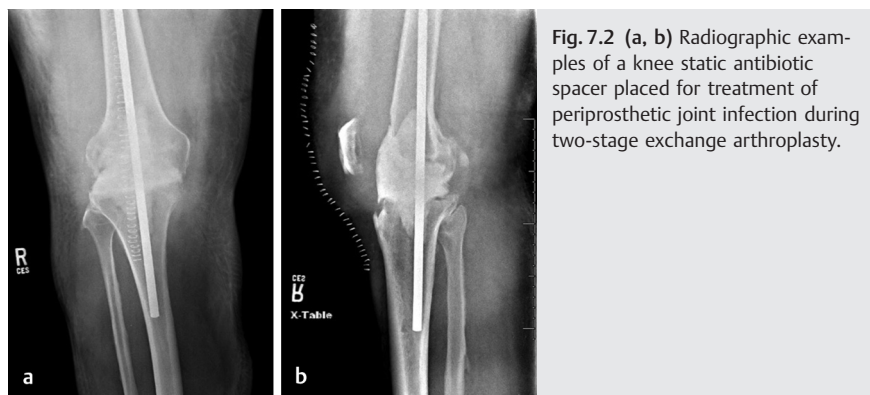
(a, b) Radiographic examples of a knee static antibiotic spacer placed for treatment of periprosthetic joint infection during two-stage exchange arthroplasty.
